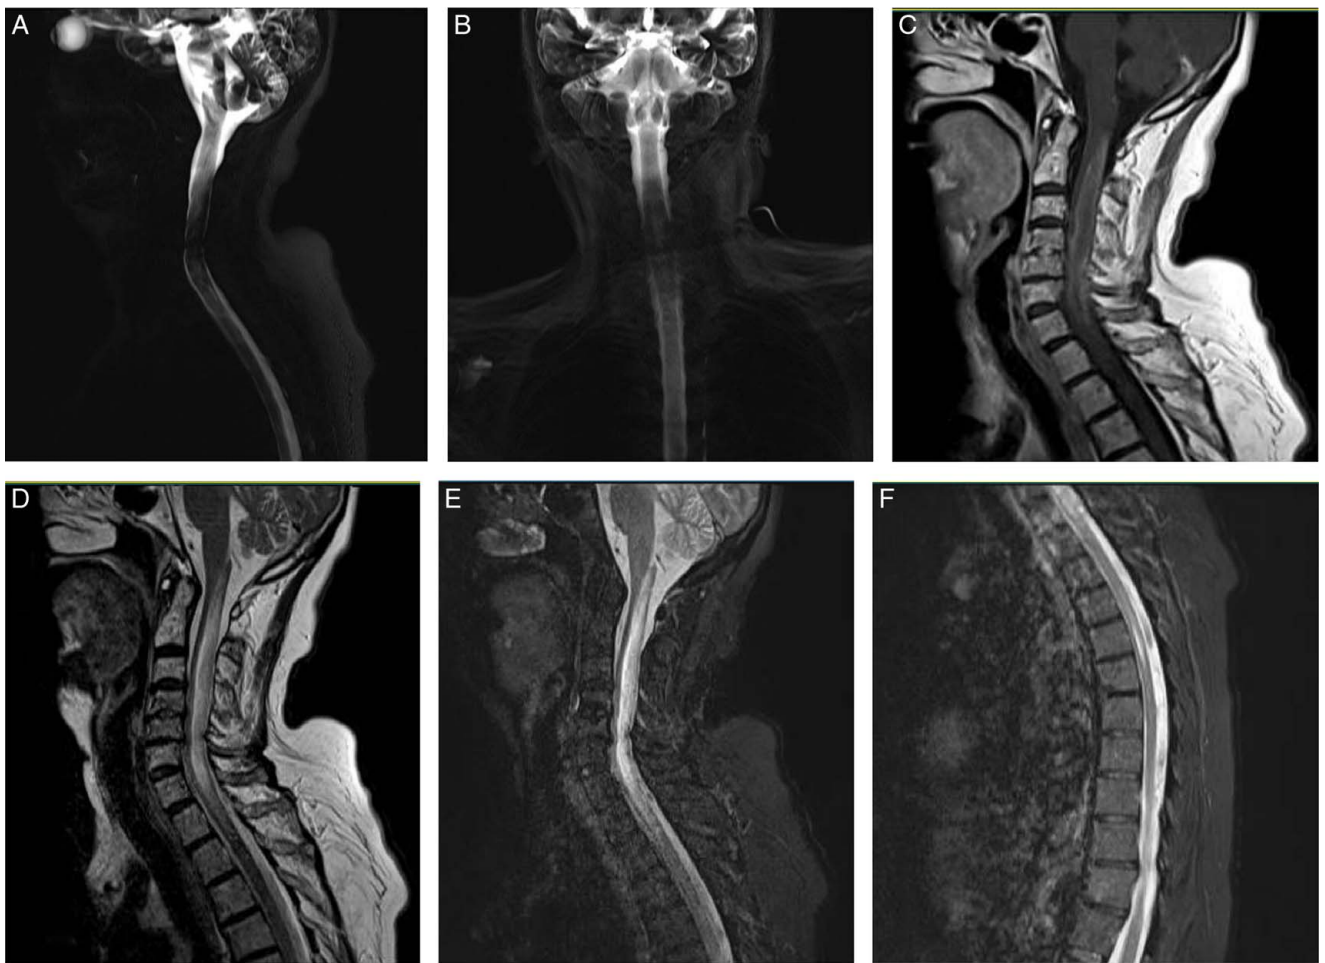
Cervical (A–E) and thoracic (F) MRI sequences demonstrating extensive cervicothoracic cord oedema compatible with both hematomyelia and myelitis of the cervical cord. Note the anterior segment of the cord is still spared.
